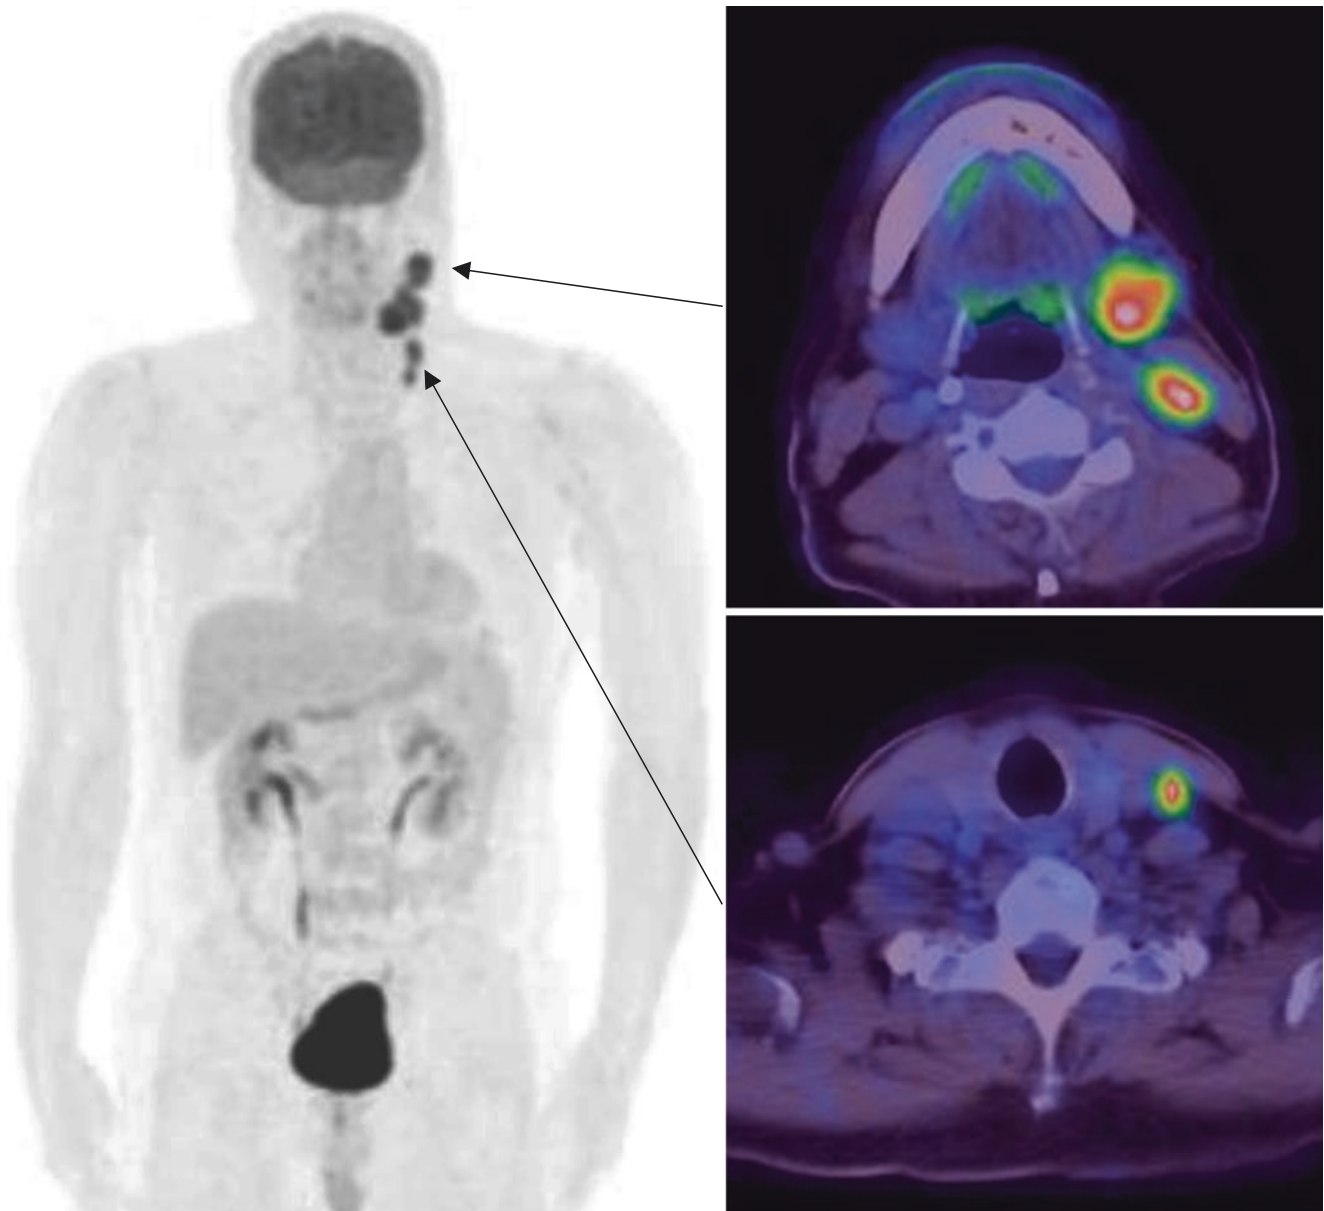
FDG PET/CT used for nodal staging. Intensely FDG avid left level 1b, level II, and left infracricoid lymph nodes are noted, in keeping with nodal metastases. No suspicious FDG-avid lesion is seen elsewhere
